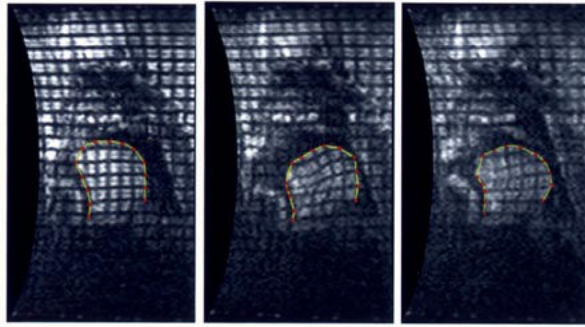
Real-time, tagged MRI images of the tongue during the syllables “sha” at 164, 350, and 600 ms. Intersection of the tags with the tongue surface are also displayed at each time frame.
